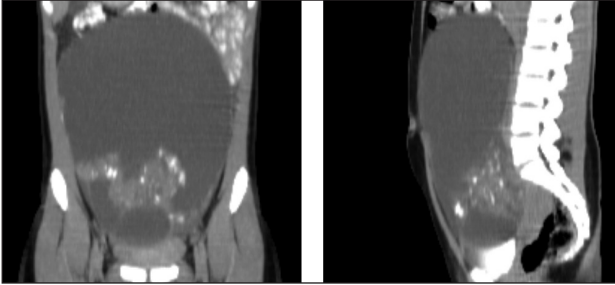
Computed tomography of the abdomen showing a large complex abdominopelvic mass of probable ovarian etiology.
